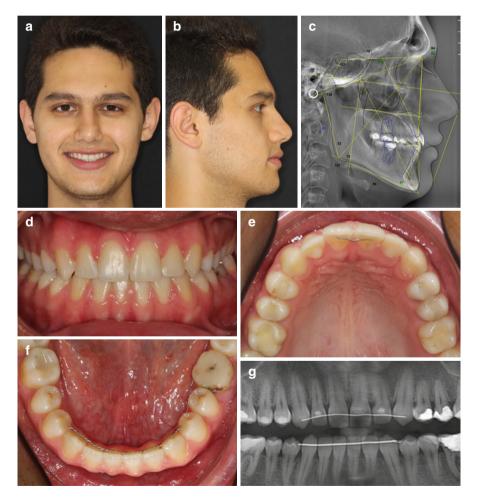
(a, b) Extraoral photographs after orthodontic and restorative treatment, (c) lateral cephalometric radiograph, (d-f) intraoral photographs, (g) panoramic radiograph (Restorations by Dr. Sehnaz Kazokoglu)
